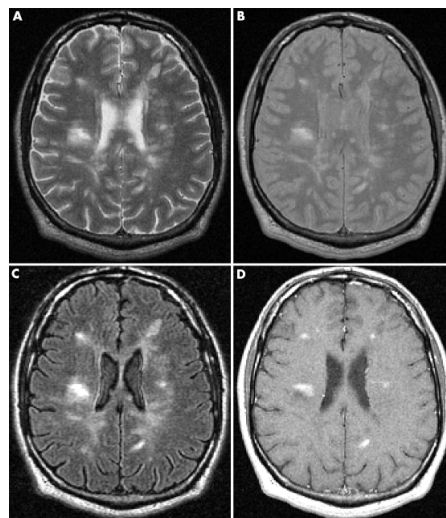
Axial magnetic resonance imaging of a 30 year old man with relapsing remitting multiple sclerosis (MS) showing multiple periventricular lesions: (A) T2 weighted image; (B) proton density weighted image; (C) fluid attenuated inversion recovery image; (D) T1 weighted image following administration of gadolinium demonstrating enhancing lesions, from [33]
